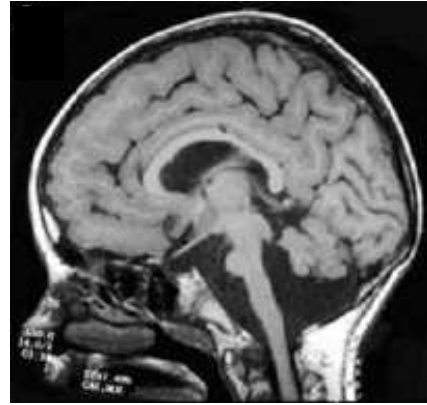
Brain MRI scans from patients with a severe dystroglycanopathy.
